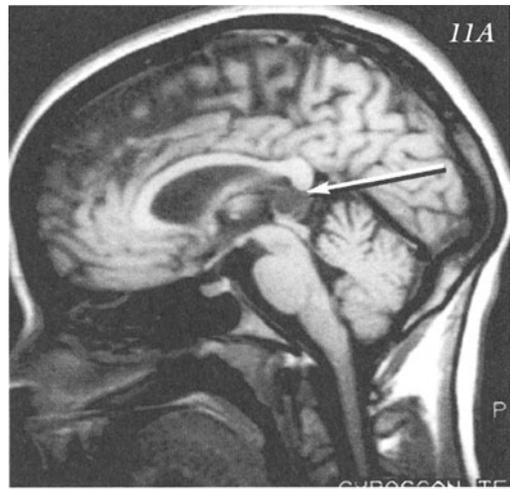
MRI: A) T1 sagittal section in a 29-year-old woman with multiple symptoms including headaches and depression but with no neurological findings. MRI/MRA was obtained because sister had an aneurysm and subarachnoid hemorrhage. This study reveals an apparently benign lesion of the pineal. B) MRI B) T1 horizontal/axial section in a young man with multiple sclerosis. No definite demyelinating lesions are demonstrated but the relationship of the mesial temporal areas to the mid brain is well demonstrated.
